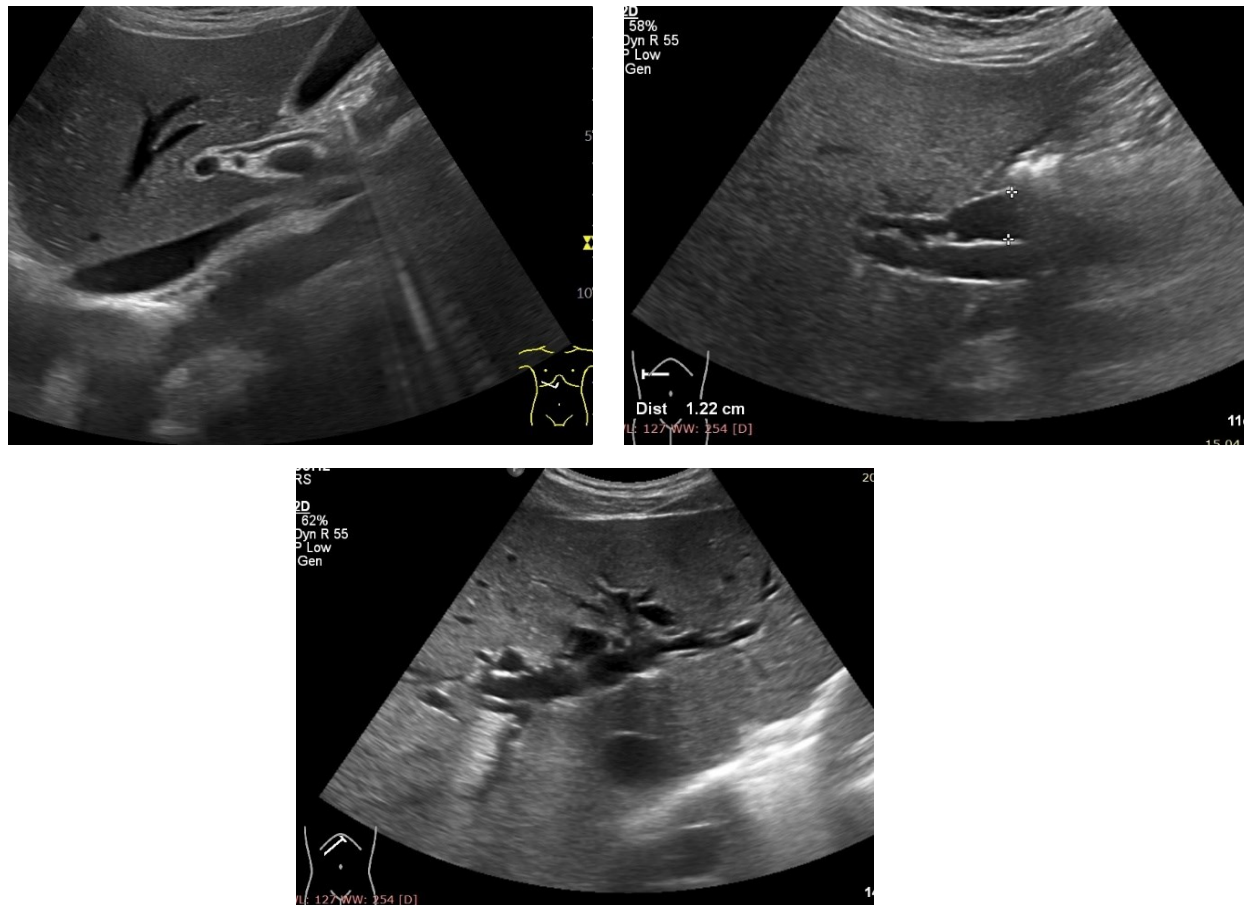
A Normal MBD; B-C. Ultrasound Findings in Obstructive Jaundice: Dilated Intrahepatic (C) and Extrahepatic Bile Ducts, Including a Prominent Common Bile Duct (>12 mm) (B)
